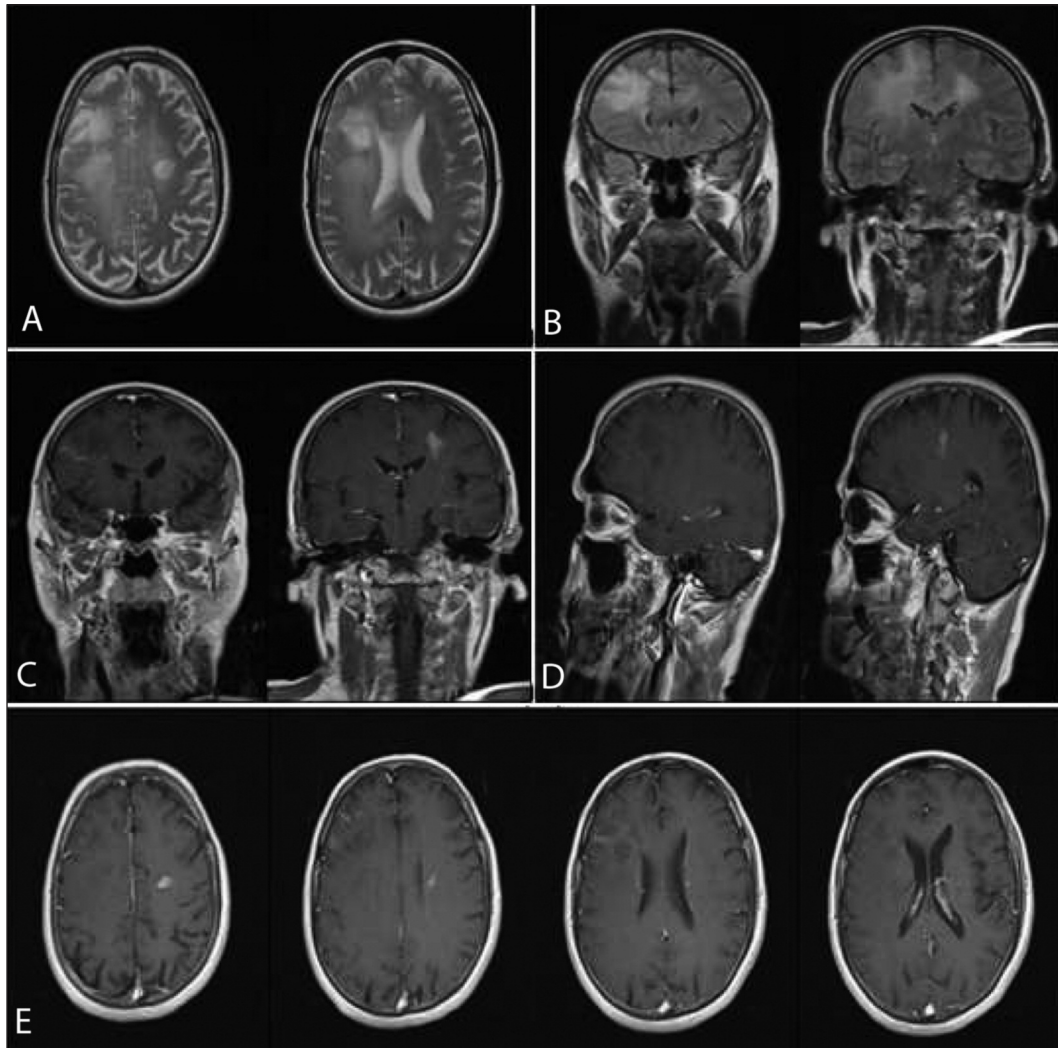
Cranial MRI, (A) T2-FLAIR axial and (B) T2-FLAIR coronal views: A cortico-subcortical irregular lesion in right internal capsule. (C) T1 with contrast coronal, (D) T1 with contrast sagittal and (E) T1 with contrast axial views: Multiple lesions, in superior and middle frontal gyri, genu of corpus callosum and in left centrum semiovale.
